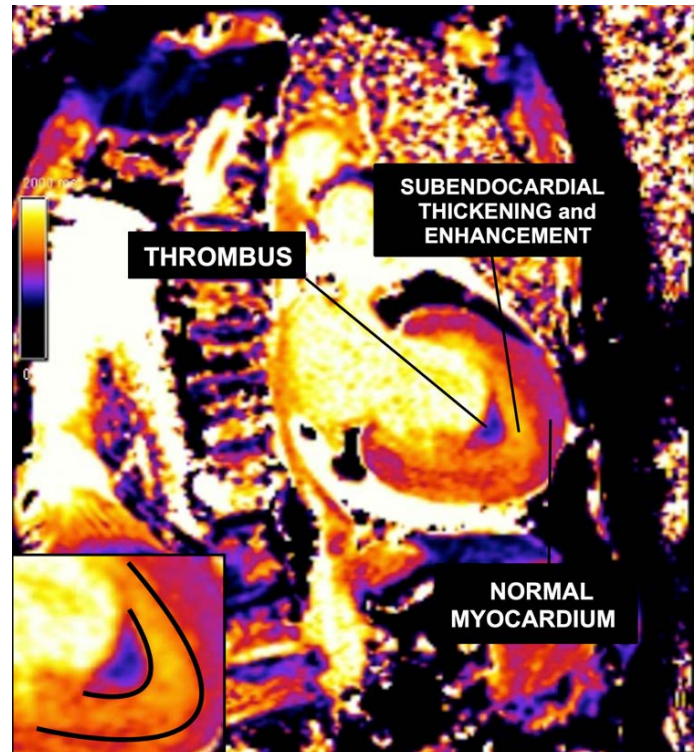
Cardiac magnetic resonance imaging demonstrating the "double V" sign (magnified area at the bottom left) at the ventricular apex. This sign is characterized by a three-layered appearance from the outer to the inner wall, consisting of normal myocardium, a thickened and contrast-enhanced subendocardium, and an overlying thrombus.
